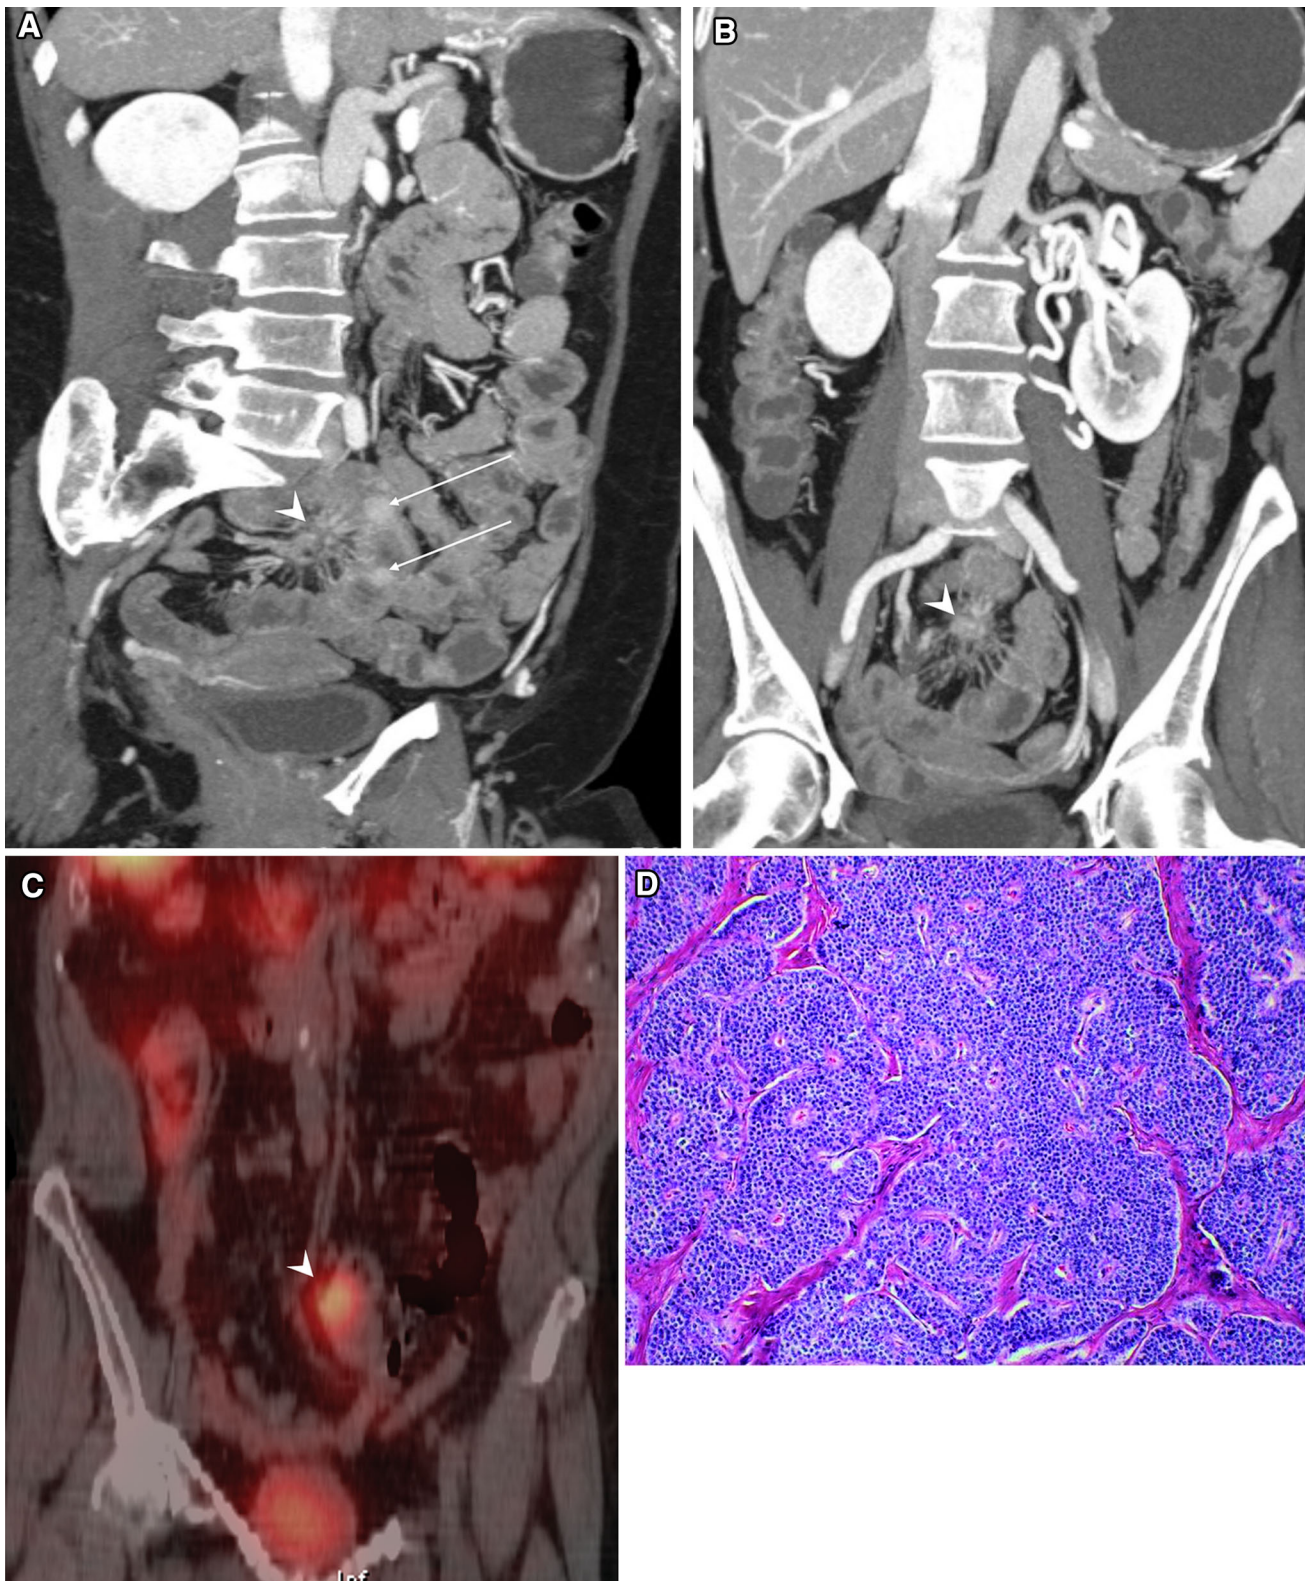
Malignant carcinoid tumor in a 53-year-old female with abdominal pain and diarrhea. Oblique sagittal (A) and coronal MIP (B) images from CTE show multiple enhancing small bowel masses (*arrows*). In addition, there is a mesenteric mass with stellate appearance tethering adjacent small bowel loops (*arrowhead*). Coronal image from octreotide SPECT/CT (C) shows
